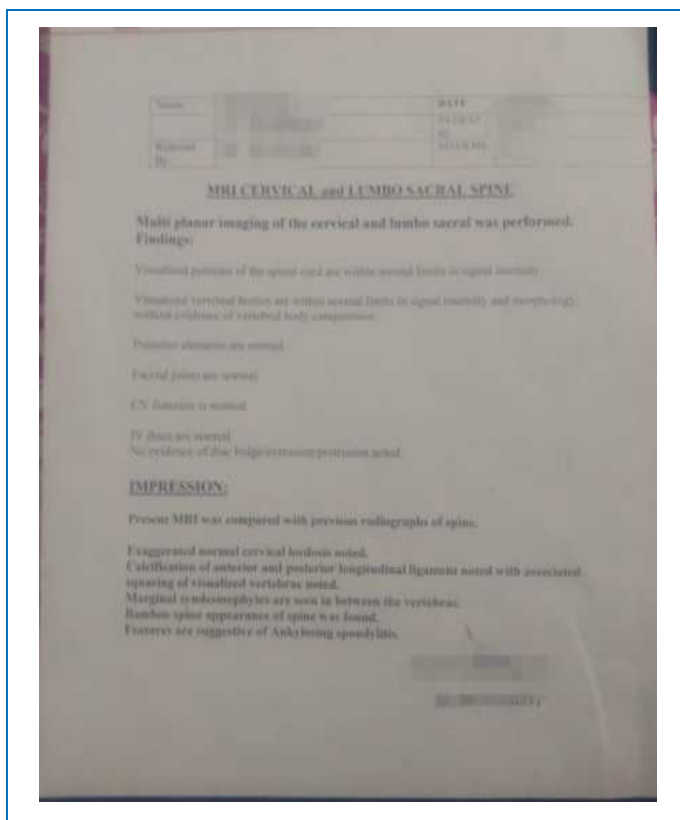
MRI - Cervical and Lumbo Sacral spine report
